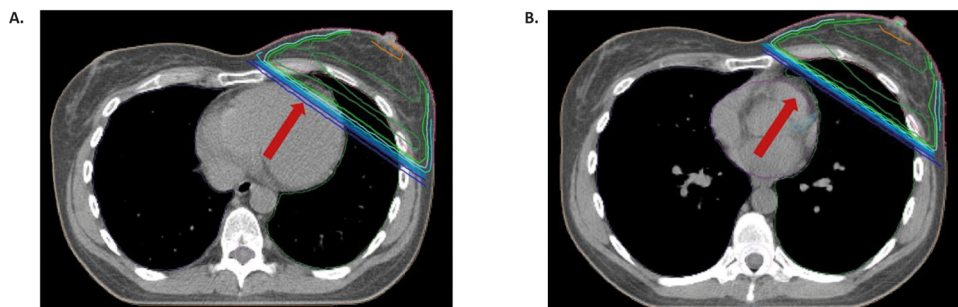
Deep inspiration breath-hold. CT-scans showing the anatomic position of the breast target volume in free-breathing (4A) and deep inspiration breath-hold (4B). (Reprinted with permission from Haussmann et al.⁶⁰)
